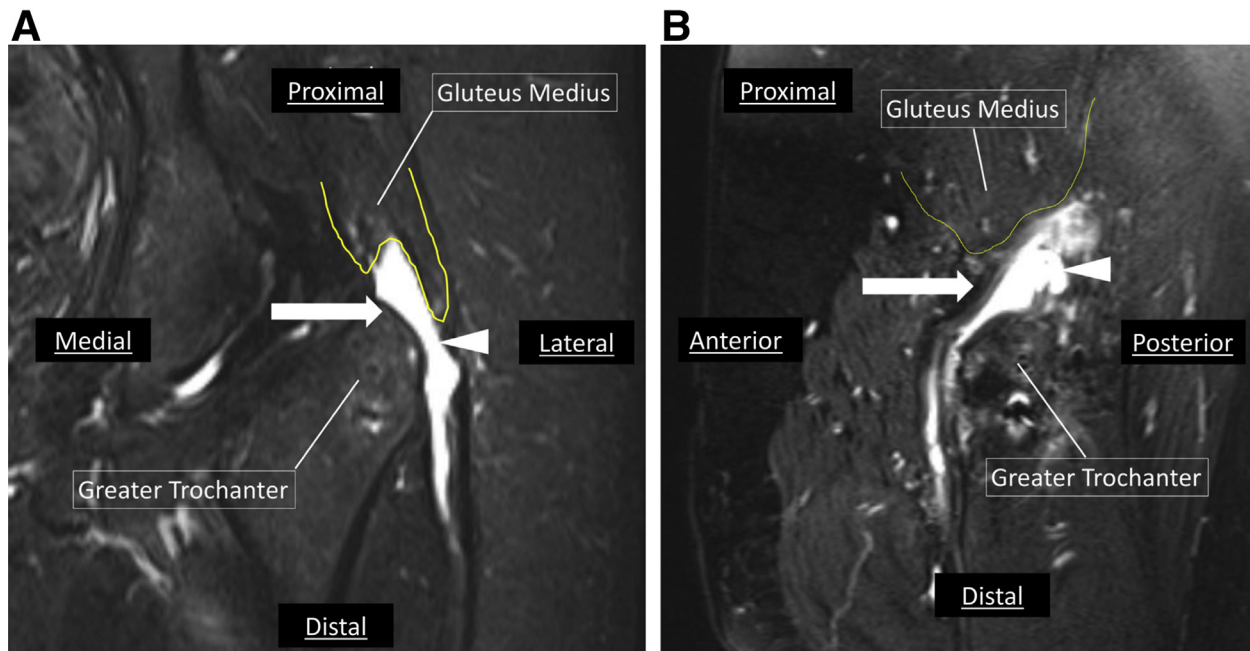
Magnetic resonance imaging (MRI) scan demonstrating a gluteus medius tear (arrows and arrowheads) of the left hip with severe bursal fluid in the (A) coronal view, (B) sagittal view. Severe retraction of the tendon affecting middle and posterior portion is observed. MRI should be used to exactly locate the tear and assess the degree of retraction. Especially, the sagittal view is critical to help locate the tear in the anteroposterior aspect of greater trochanter. Yellow line = proximal retraction of the gluteus medius.
